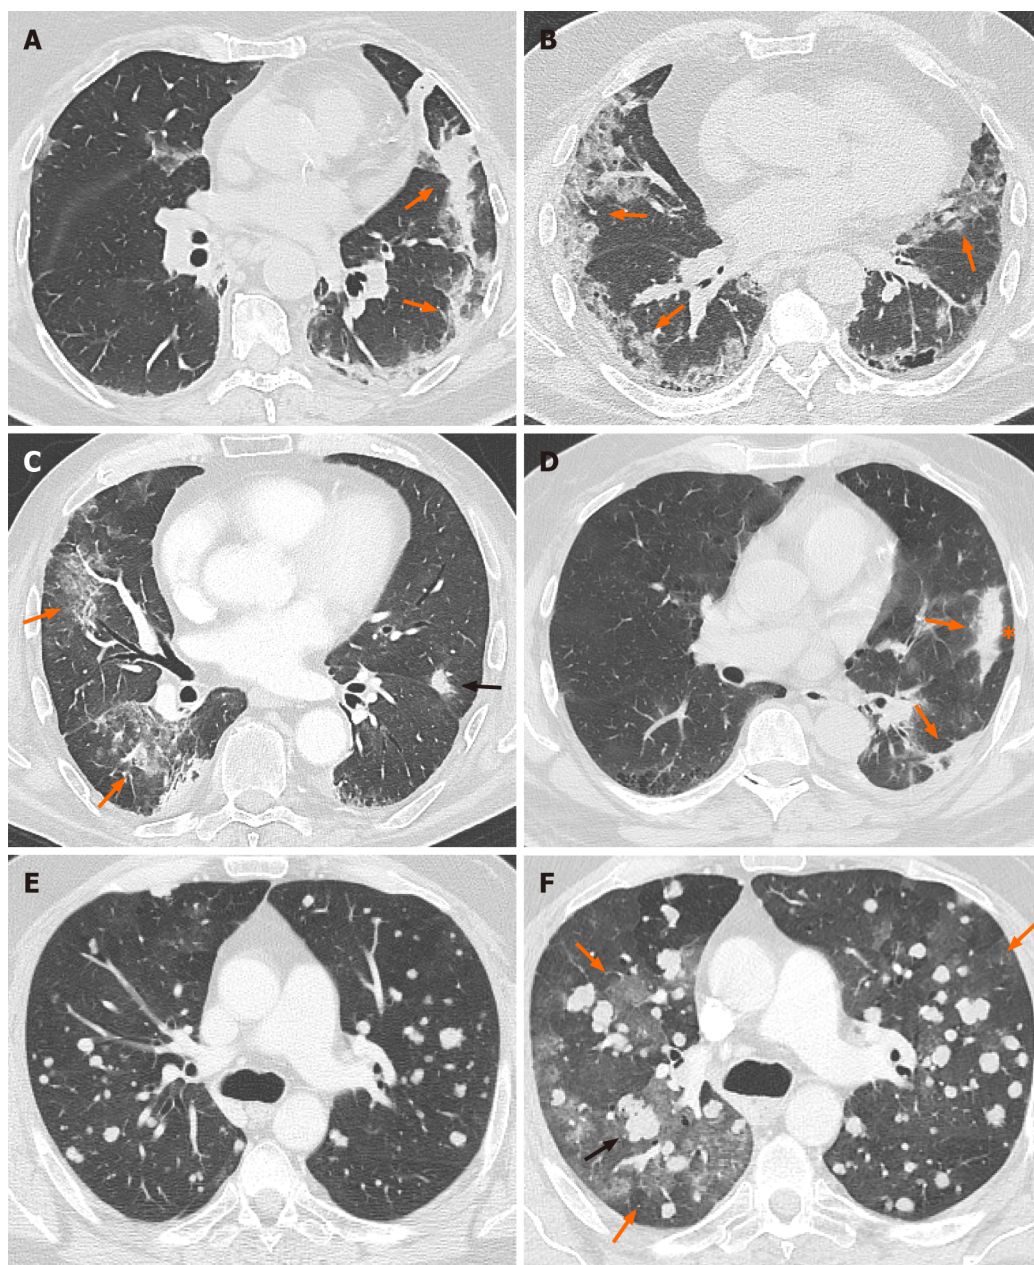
Axial computed tomography image. A: Axial computed tomography (CT) image of a 45-year-old patient with coronavirus disease 2019 showing left peripheral consolidation with perilobular distribution (arrows) suggesting organizing pneumonia; B: Axial CT image showing bilateral ground-glass opacities distributed in the subpleural regions (arrows) in a renal cancer patient confirmed with coronavirus disease 2019 pneumonia; C: Axial CT image showing multifocal ground-glass opacities in the right lung (orange arrows) and nodular consolidation (black arrow) in a renal cancer patient diagnosed with immune-related pneumonitis after treatment with nivolumab; D: Axial CT image of a patient suffering from immune-related pneumonitis showing multifocal, bandlike consolidation in the left lower lobe (arrows) with peripheral sparing (asterisk) suggesting organizing pneumonia; E and F: The last is a case of immune-related pneumonitis in a patient undergoing ipilimumab plus nivolumab for metastatic soft tissue sarcoma, whose baseline axial CT image (E) shows bilateral solid metastatic nodules; the axial CT image obtained after starting immunotherapy (F) shows new multifocal ground-glass opacities (orange arrows) with interval enlargement and an increasing number of pulmonary nodules (black arrow).
